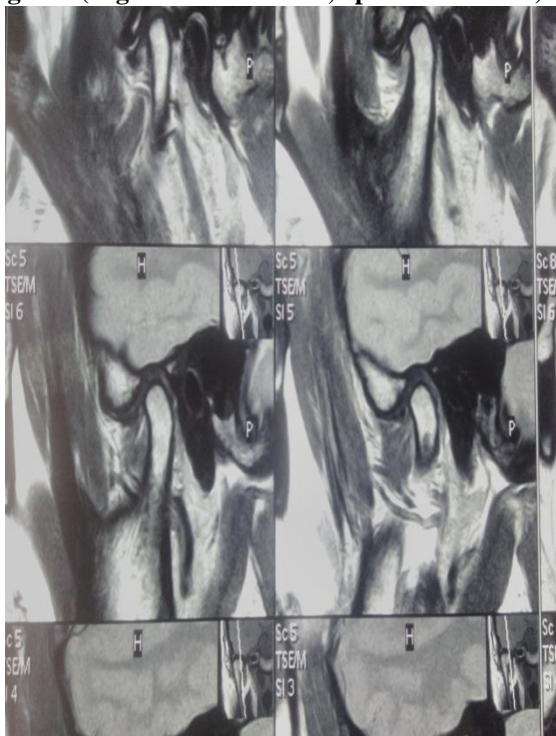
(right side TMJ MRI close mouth view)
